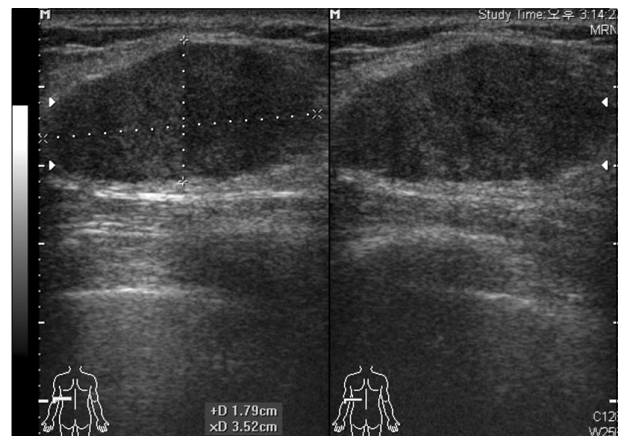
Ultrasonography shows an ill-defined and markedly hypoechoic mass with posterior acoustic shadowing and a surrounding hyperechoic halo.
